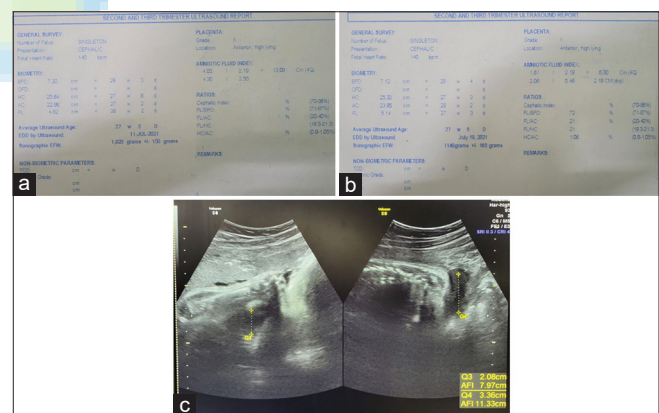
(a) Pelvic ultrasound (April 16, 2021): Pregnancy uterine 27 weeks and 5 days age of gestation, cephalic, with good cardiac and somatic activities, Normohydramnios, AFI: 13.9, placenta anterior Grade 2 high lying with visualization of subplacental sonolucency, estimated fetal weight 1028 ± 150 g Appropriate for gestational age. (b) Pelvic Ultrasound (April 23, 2021): Pregnancy uterine 27 and 6 weeks by average fetal biometry. Live, singleton in cephalic presentation with good cardiac and somatic activities. Placenta anterior, Grade 2, high lying, with visualization of subplacental sonolucency. Amniotic fluid index is below the 5th percentile for age of gestation at 6.3 centimeters. Estimated fetal weight is appropriate for gestational age at 1148 ± 168 g. (c) Biophysical Score (May 25, 2021): Pregnancy uterine 32 weeks and 1 day by average fetal biometry. Live singleton, in cephalic presentation with good cardiac and somatic activities. Placenta anterior, Grade 2, high lying, with visualization of subplacental sonolucency. Normohydramnios at 11.33 centimeters by deepest vertical pocket. Estimated fetal weight is appropriate for gestational age at 1734 ± 253 g. Biophysical score 8/8. AFI: Amniotic fluid index
